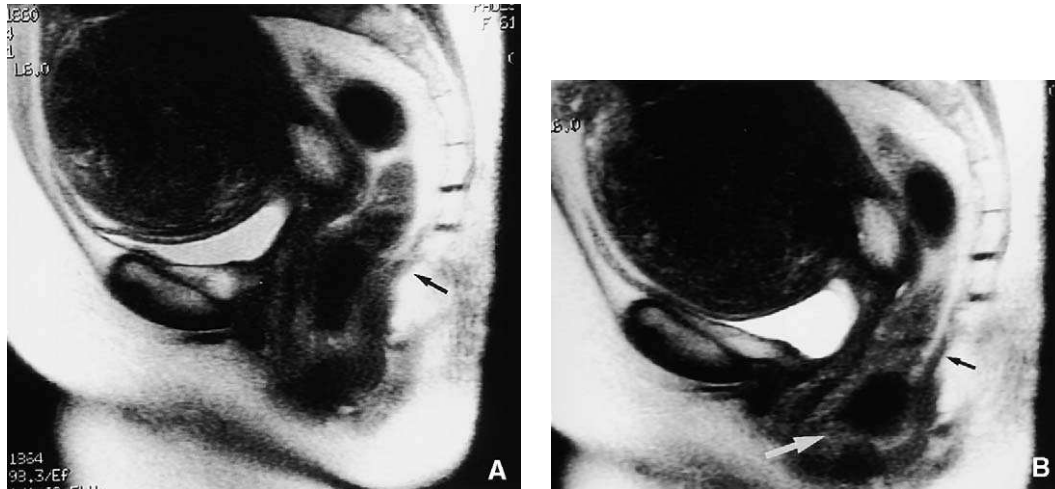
A 63-year-old woman complained of incomplete bowel evacuation and pelvic pressure. Sagittal T2-weighted (2200/96) MR image at rest (A) and at strain (B) show a large fibroid that is likely preventing descent of the anterior and middle compartments. The levator plate is vertically oriented (black arrow), and there is development of a rectocele (white arrow), which indicates significant damage to the posterior compartment. (From Fielding JR. Practical MR imaging of female pelvic floor weakness. Radiographics 2002;2:295–304; with permission.)
